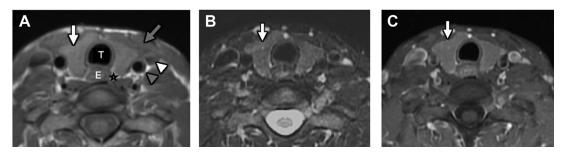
MR imaging of thyroid. (*A*) T1-weighted axial MR image of thyroid (*white arrow*) is slightly hyperintense compared with adjacent strap muscles (*gray arrow*). Esophagus (E) is posterior to thyroid, and trachea (T) is anterior to the esophagus. Internal jugular vein (*white arrowhead*) is lateral to thyroid and common carotid artery (*gray arrowhead*). The tracheoesophageal groove (*star*) is the fat between the trachea, esophagus, and thyroid. (*B*) T2-weighted MR image shows that the thyroid (*white arrow*) is hyperintense to adjacent strap muscles (*gray arrow*). (*C*) T1-weighted, contrast-enhanced, fat-saturated axial MR image shows normal thyroid (*white arrow*) enhancement.
